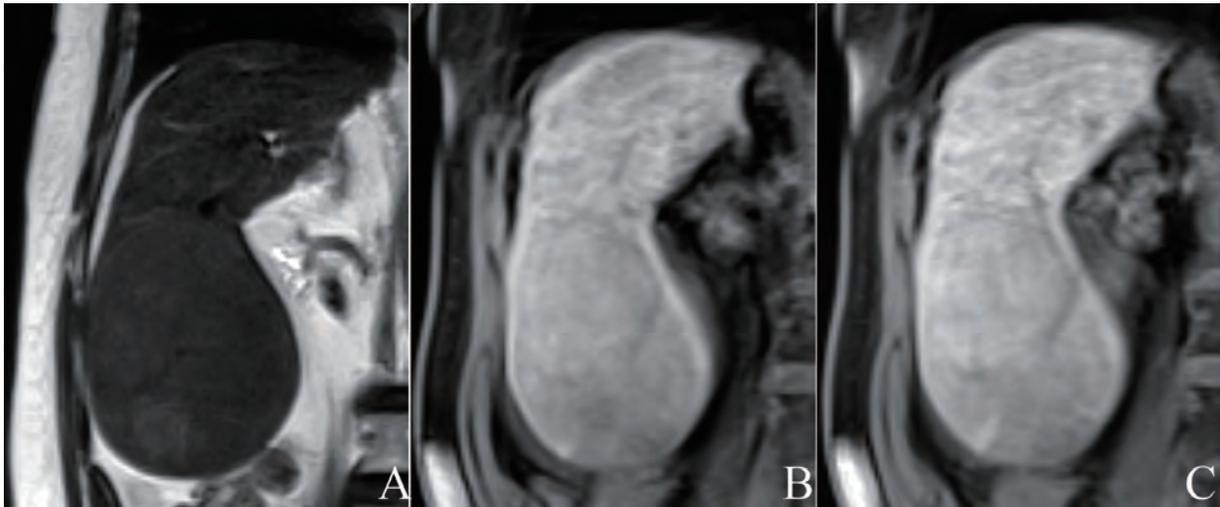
Follow-up contrast-enhanced MRI with gadoxetic acid. (A) Precontrast coronal T2-weighted image shows an oval, well-circumscribed iso-signal mass in segment VI of the liver. (B) Delayed 20 m hepatobiliary phase in the gadoxetic acid-enhanced MRI shows a slightly hyperenhanced mass and surrounding liver cirrhosis with heterogeneous. (C) Delayed 30 m hepatobiliary phase in the gadoxetic acid-enhanced MRI shows a persistent slightly hyperenhanced mass. MRI, magnetic resonance imaging.
